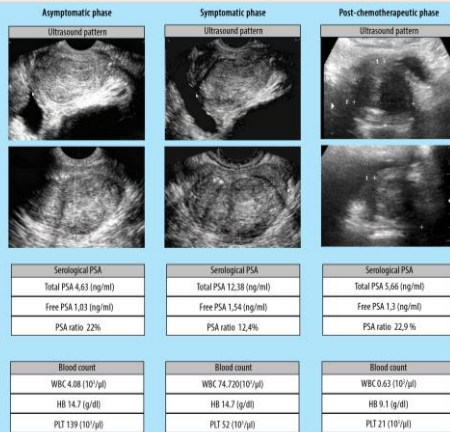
The image represents in chronological order three groups of data of the case reported: ultrasound prostate pattern, serological level of PSA and mean values of blood count all collected in the asymptomatic phase related to leukemia but with only LUTS symptoms, in the symptomatic phase weakness and nocturnal low-grade fever) of leukemia and after the first cycle of chemotherapy.
